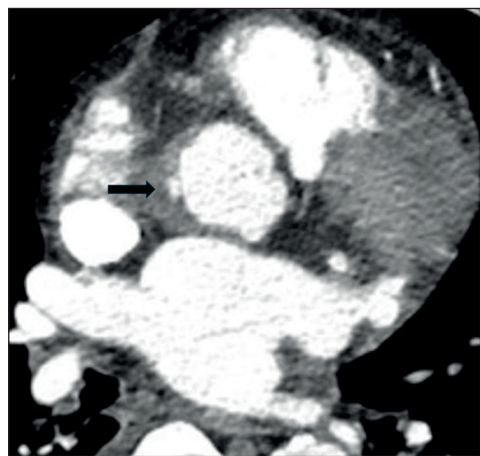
Abscess formation (arrow) on cardiac computed tomography in axial projection.
